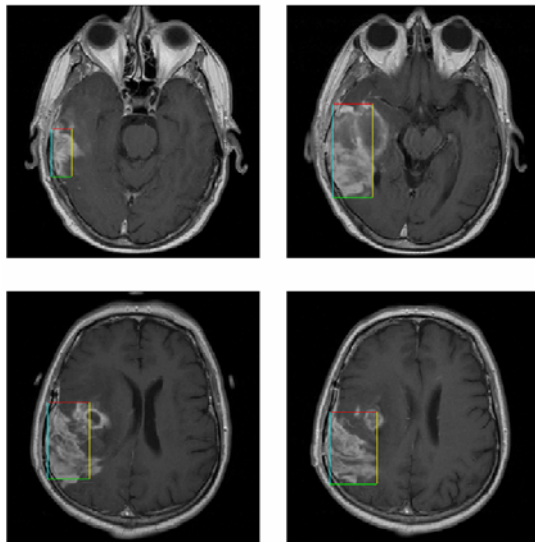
MR images and bounding boxes around abnormal regions.
